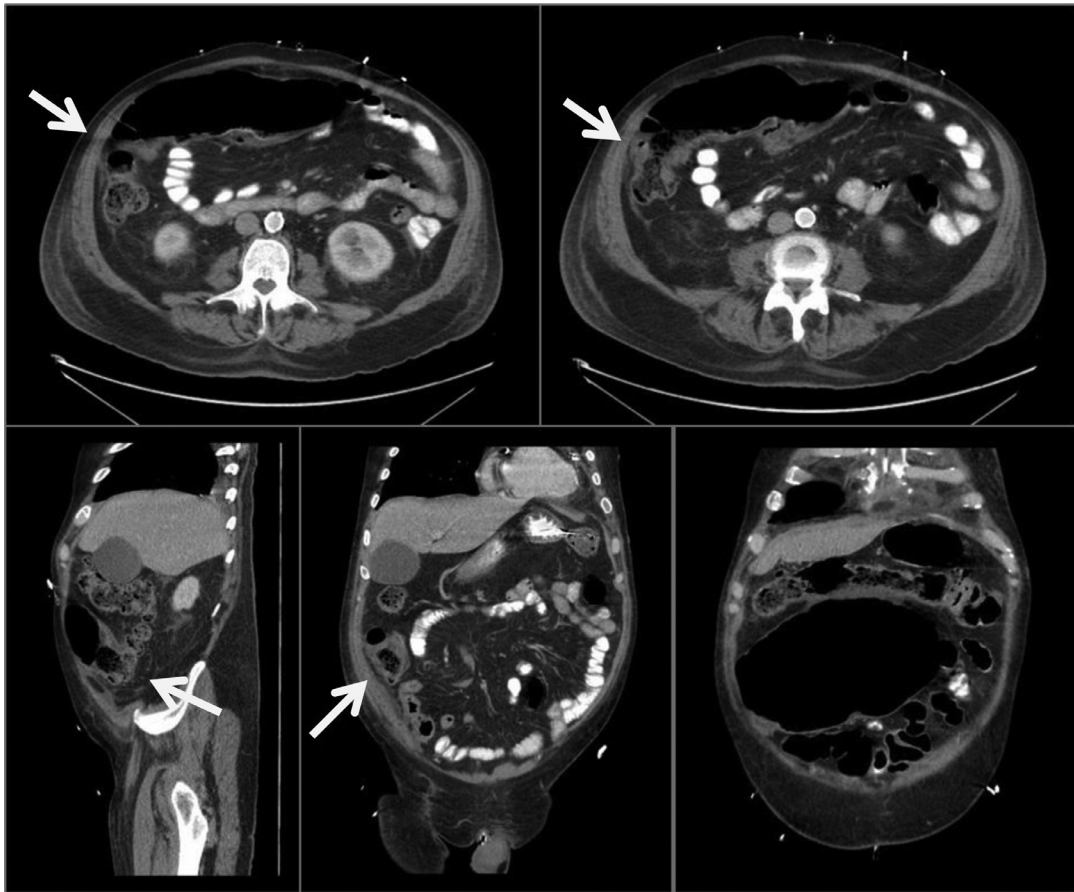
Multiplanar computed tomography images demonstrating cecal volvulus, with a markedly dilated cecum which is folded on the ascending colon, resulting in a transition point (arrow).
